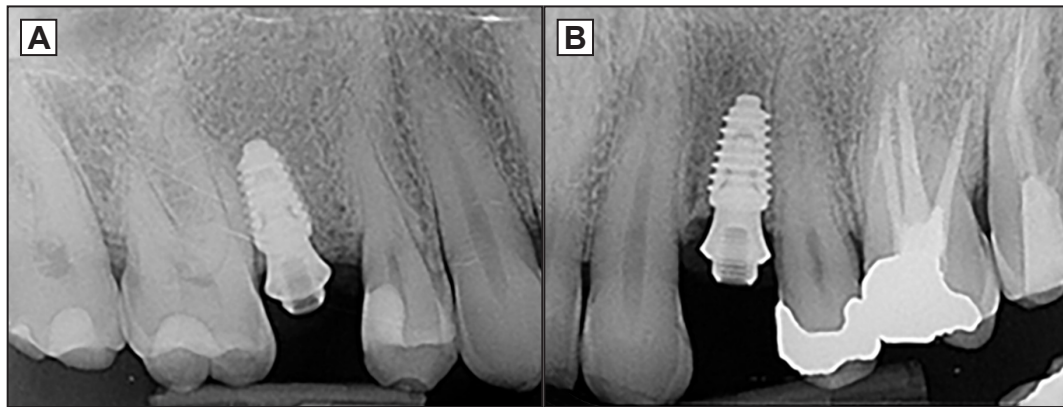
Postoperative radiographs of implants in sites: A = electromagnetic osteotomes; B = osseodensification burs
